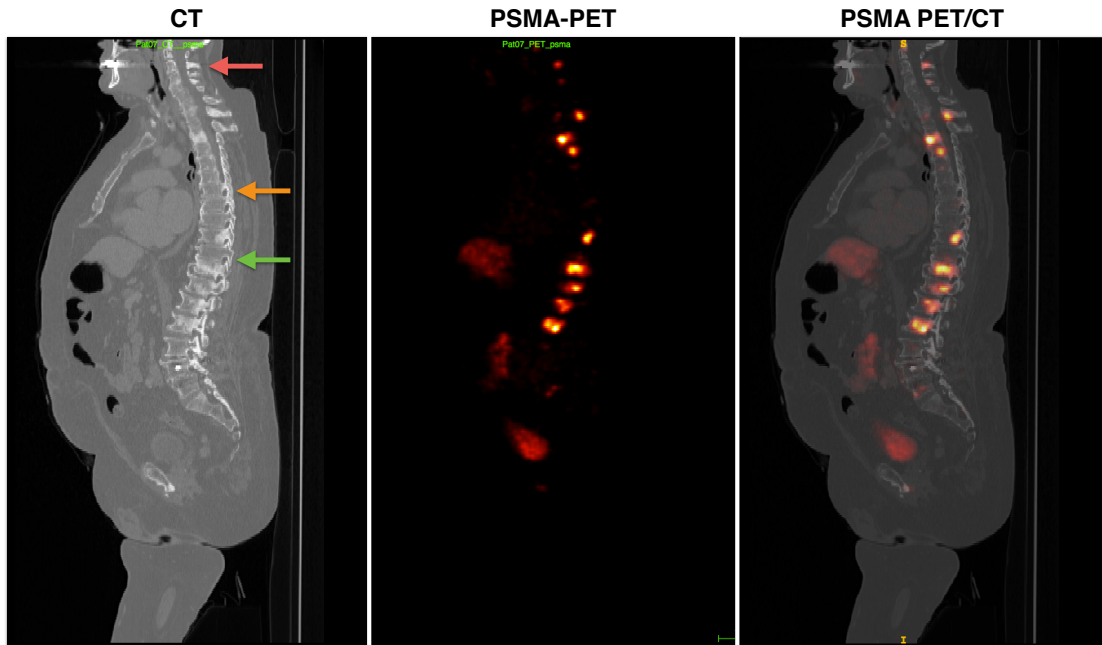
A hybrid PSMA-PET/CT scan. The CT scan (left) provides high-resolution anatomical information, while PET scan (middle) highly-specific metabolic description. Since the scans were acquired at the same scanner, they are naturally aligned. An overlay of the CT and PET scans (right) simplifies localization of regions with high tracer uptake, highlighting prostate metastatic lesions inside the spine. The metabolic information enables to discriminate between malignant (green arrow) and benign lesions (orange arrow), although both are manifested by reduced bone density in the CT scan. Moreover, the small tumor in the cervical spine (red arrow) did not yet alter the bone density significantly and thus it might be missed in the CT scan.
